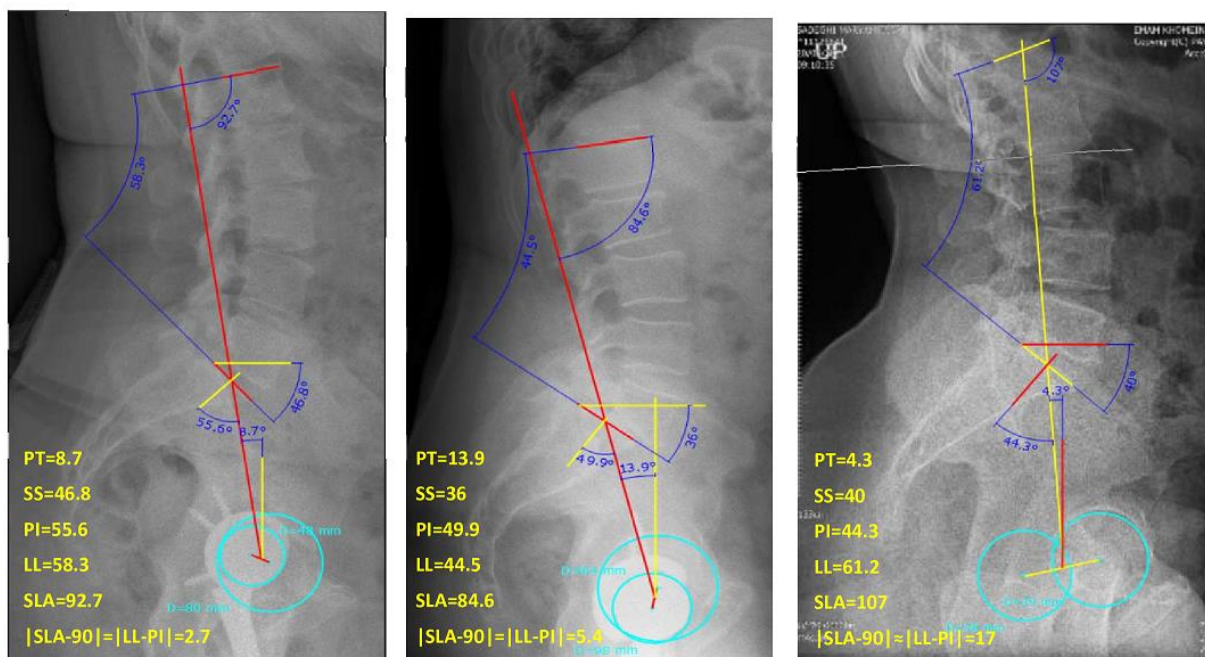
Measurement of spinopelvic angles, including Pelvic Tilt (PT), Pelvic Incidence (PI), Sacral Slope (SS), Lumbar Lordosis (LL), and Pelvico-Sacro-L1 Angles, on preoperative X-rays
